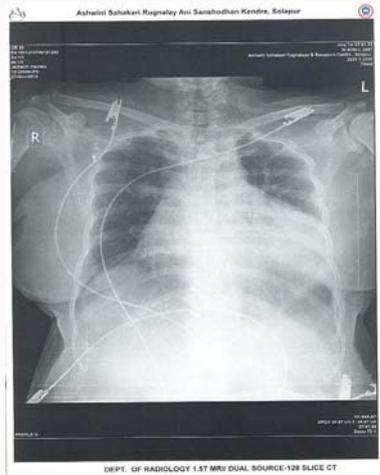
Chest X-ray showing cardiomegaly and left pleural effusion.
